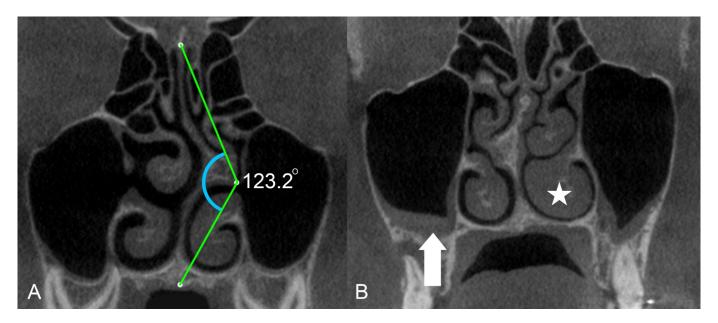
In the coronal cone beam computed tomography (CBCT) images. (A) For Nasal Septum Deviation (NSD), measuring the angle is defined as the one formed between three anatomical points: the point where the nasal septum crosses the floor of the nasal cavity, the crista galli, and the most convex part of the septum in the coronal plane. (B) The arrow shows mucosal thickening in the right maxillary sinus, and the asterisk shows left inferior concha hypertrophy.
